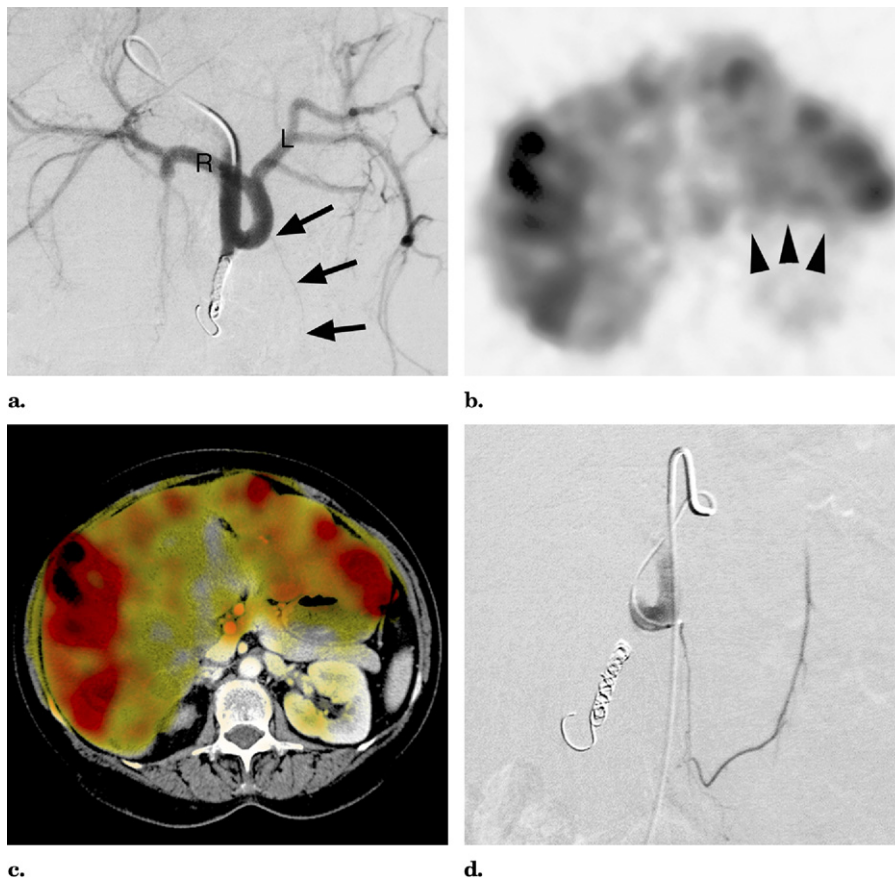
A 61-year-old woman with retroperitoneal leiomyosarcoma metastatic to bone, lungs, and liver had undergone surgical resection of the primary tumor with adjuvant radiotherapy, multiple regimens of systemic chemotherapy including ifosfamide, doxorubicin, dacarbazine, temozolomide, gemcitabine, docetaxel, and sorafenib, and radiotherapy to osseous metastases. The hepatic metastases had progressed to the point of enlarging the liver to a volume of approximately 4 liters. (a) Common hepatic artery DSA after embolization of the GDA showed leftward deviation of the proper hepatic artery caused by massive enlargement of the liver, and both the right (R) and left (L) hepatic arteries originating from the left upper quadrant. The RGA originated from the proper hepatic artery to the left of the GDA (arrows) but was not identified by the operators during the procedure because of the distortion and displacement of vessels. (b) Deposition of $^{99m}\text{TcMAA}$ in the anterior lesser curve of the stomach (arrowheads) was revealed by SPECT scintigraphy, but required careful registration onto a previous CT scan to confirm extrahepatic location (c). This was one of only three patients in whom scintigraphy identified extrahepatic deposition. (d) The artery was identified 15 days later at the time of radioembolic microsphere administration and was selected and coil embolized. This patient also underwent single-session whole-liver administration from the proper hepatic artery without gastrointestinal complications.
